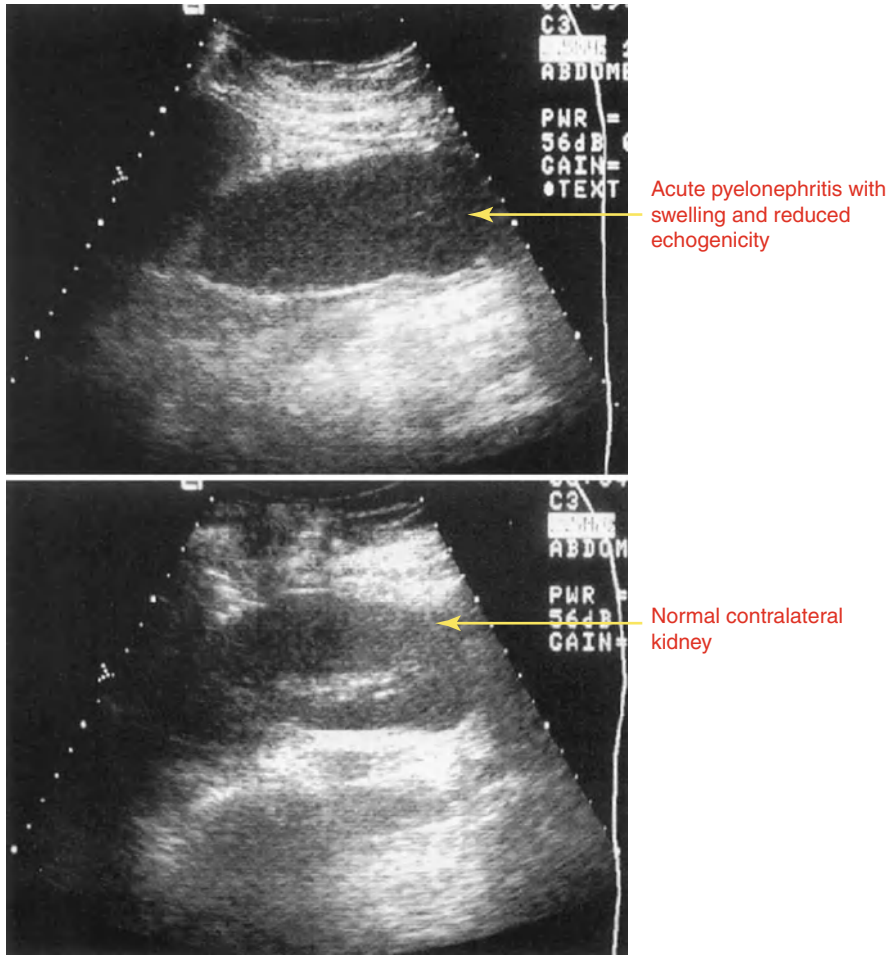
Ultrasound – acute pyelonephritis
